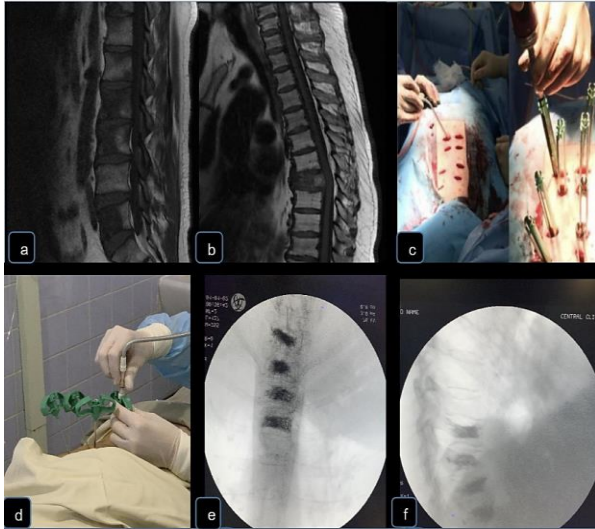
a) Multilevel lumbar metastasis; b) Magnetic resonance imaging (MRI) of thoracolumbar metastasis; c) Placement of percutaneous pedicle screws; d) Placement of cement over the guide after 3-5 minutes of drying; e and f) Multilevel axial and lateral vertebral correction for stabilization and pain control in the spine (With permission from the Petrovsky National Research Center of Spinal Surgery and Neurosurgery, Moscow, Russia)
